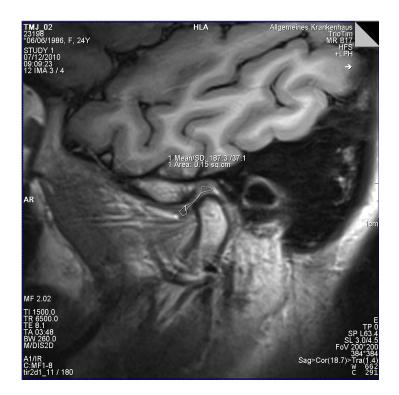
MRI of the volunteer: left TMJ with ROI drawn. T₁ mean value and standard deviation (SD) are displayed above ROI. Sequence parameters are depicted on the Figure as well.
